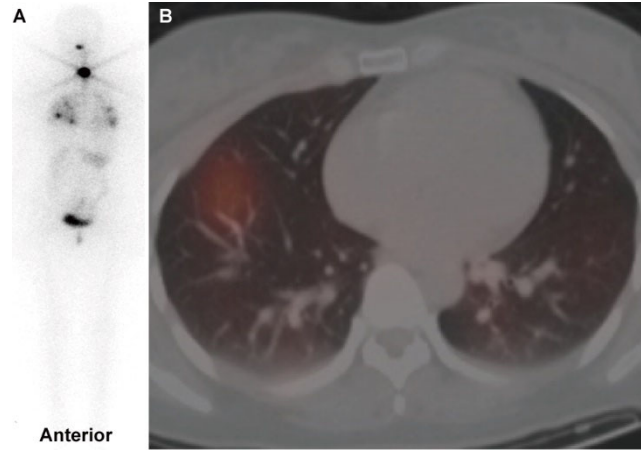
Post radioiodine adjuvant therapy whole-body scan (A) and SPECT/CT fusion image (B) of a papillary thyroid carcinoma patient with unexplained hyperthyroglobulinemia causally attributed to thyroid remnant.
